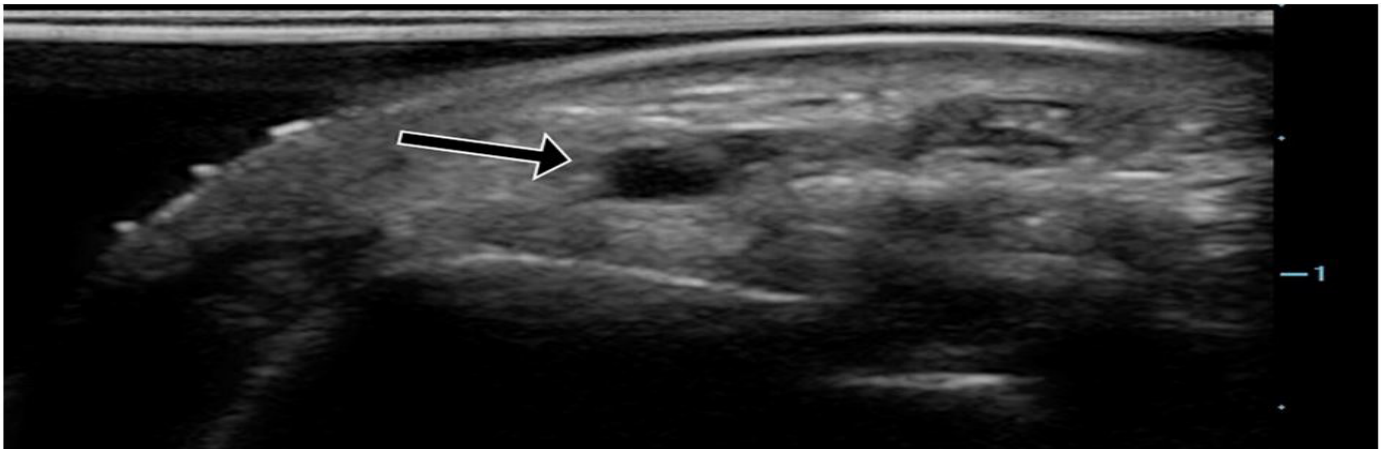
Ultrasound of the radial artery showing normal anatomy (arrow).
